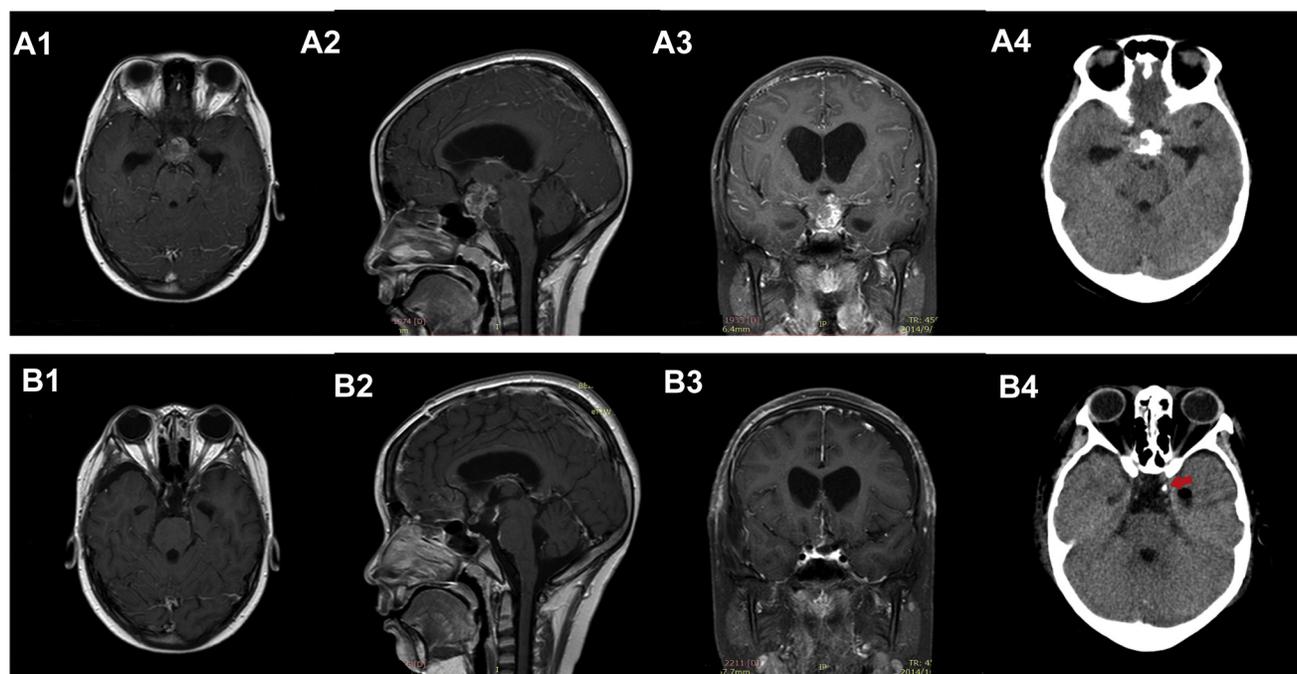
A 9-year-old girl presented with right-eye blurred vision lasting for 20 days. Magnetic resonance imaging revealed the presence of a cystic and solid tumor localized in the intrasellar, suprasellar, third ventricle, and pontine cistern area. The tumor slightly oppressed the brain stem and invaded the pituitary stalk, leading to obstructive hydrocephalus (A1–A3).
